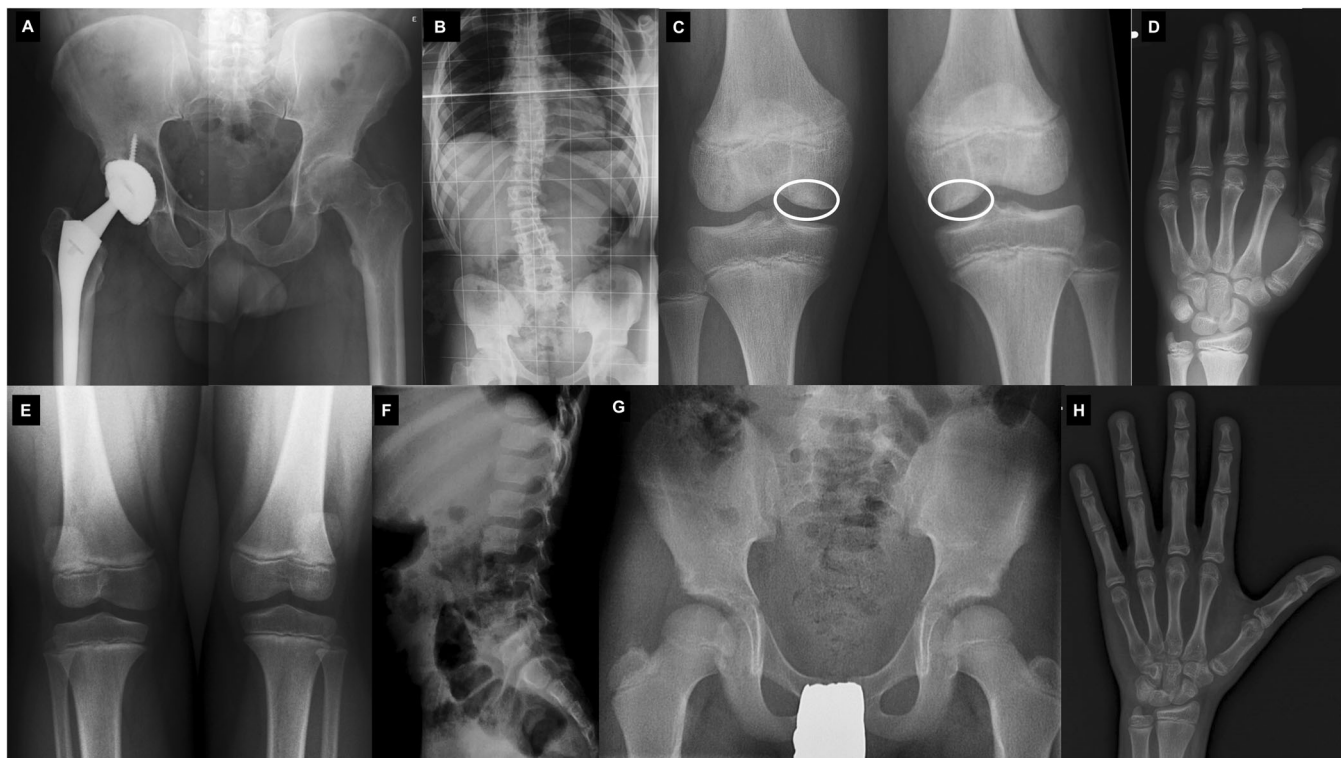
(A) Hip radiograph from *Proband's 1 father* at age 57 years old. Total arthroplasty is present at the right hip. The left hip also shows signs of degenerative articular disease, mild deformity of femoral head with osteophytes, joint space narrowing and subchondral sclerosis. (B) Mild capital femoral changes and lumbar scoliosis are present in *Proband's 1 cousin* at the age of 18. (C) Knee radiographs from *Proband 2*. Bilateral osteochondral fragments are seen in both medial femoral condyles, corresponding to osteochondritis dissecans (ovals). The fragments are not displaced and there is no sign of instability. (D) Hand and wrist radiograph from *Proband 2* at 11.5 years old. Bone age corresponds to a 12.5-year-old male. Mildly broad and short first metacarpal and slightly short and diverted distal phalanges (2nd and 3rd) are shown. (E) Knee radiographs from *Proband 3*. No osteochondral knee defects are noted. Radiographs from *Proband 4*. (F) Lateral lumbar spine radiograph at 7 years. No spinal features are seen. (G) Normal hips at 8 years. (H) Hand and wrist at 14 years; no epiphyseal defects or brachydactyly. Bone age corresponds with chronological age.
